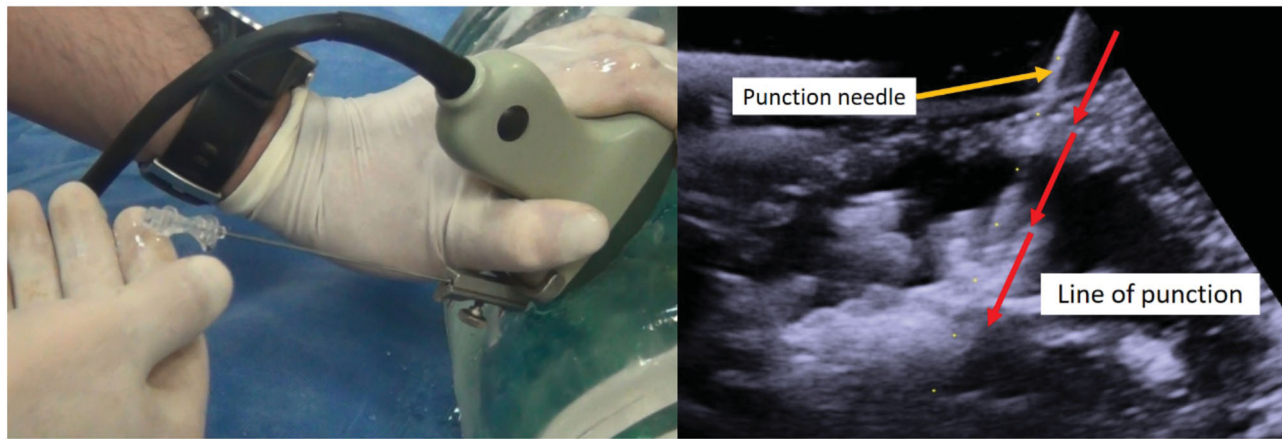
Ultrasound-guided renal access (A) Ultrasound-guided puncture. (B) Echogenic picture of nonbiological 3D printed kidney model and puncture needle.
